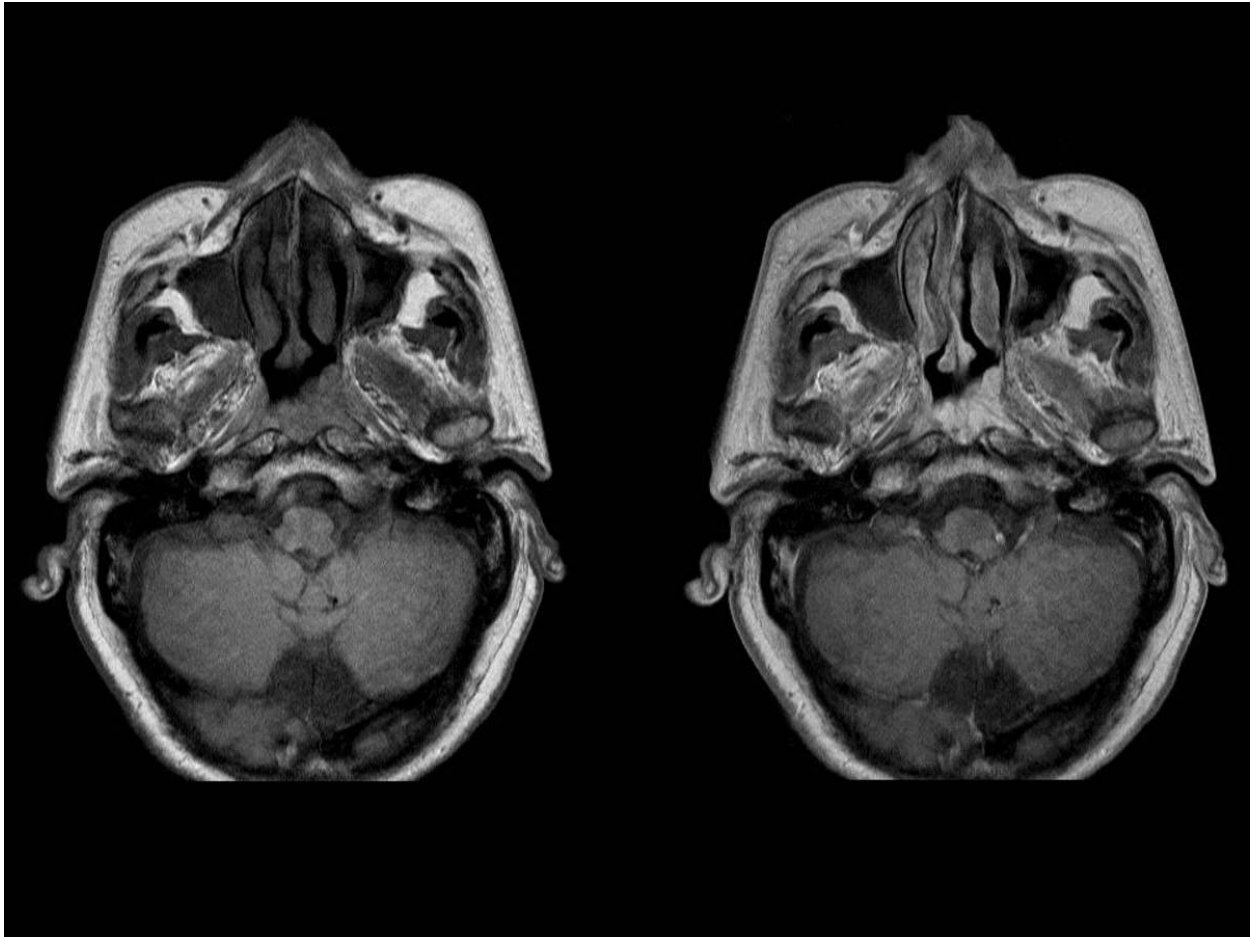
Retropharyngeal lipoma. Axial computed tomography images of a 63 year- old man presenting with obstructive sleep apnoea, demonstrate a well-defined homogenous fat density mass with thin septa that didn't enhance in the retropharyngeal space. There is no clearly identifiable capsule. The lesion produces mass effect on the airway.
